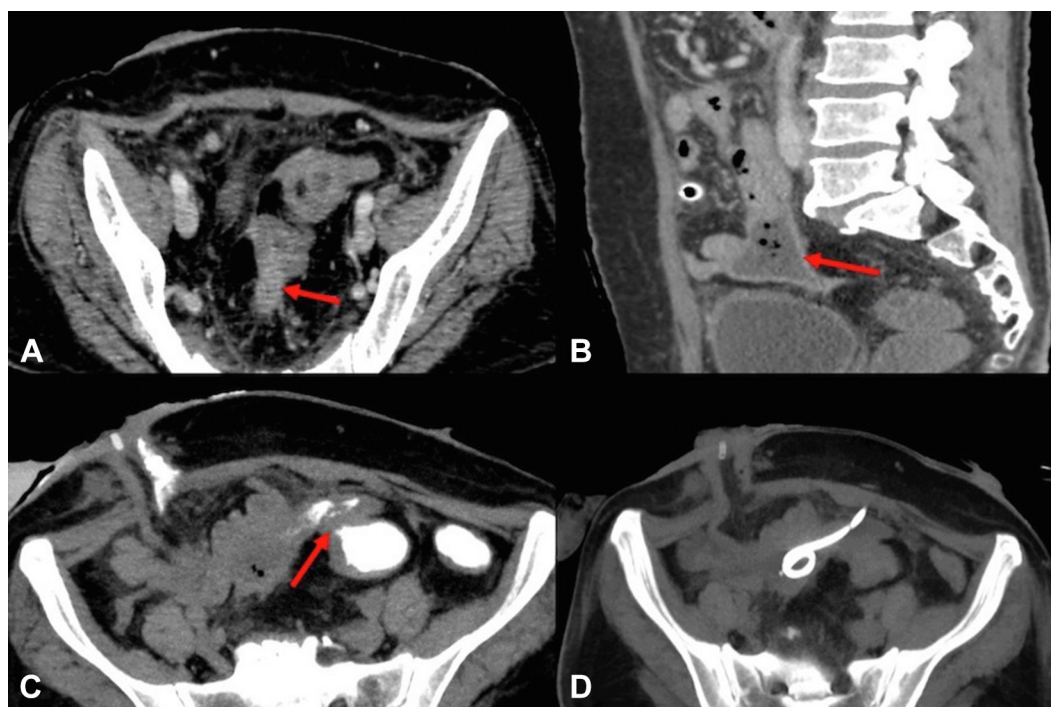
A, Images of contrast-enhanced CT of the abdomen demonstrating a short stricture approximately 1 cm long at the recto-sigmoid junction (*red arrow*). B, Paracolic/pelvic collection with air foci adjacent to the sigmoid colon (*red arrow*). C, Fistulous communication between the area just proximal to the stricture and the adjacent collection (*red arrow*). D, Percutaneous pigtail drainage catheter placed in the collection.
